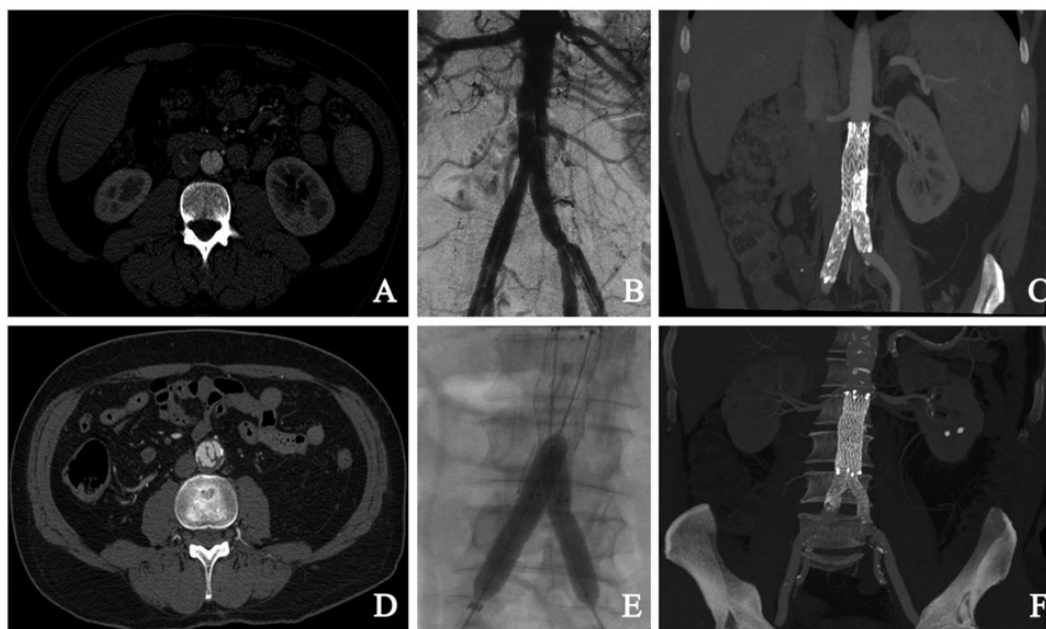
Preoperative CTA showing “double-barreled” appearance of the abdominal aorta (a). Completion angiogram after bifurcated stent graft deployment (b). CTA 8 years after treatment showing good placement of the stent graft without any recurrence (c). CT scan axial image showing abdominal aortic dissection involving to iliac arteries (d). Intraoperative digital subtraction angiography demonstrating good placement of aortic and kissing bare metal stents (e). Postoperative CT scan showing good patency of aortic and iliac stents and complete disappearance of false lumen (f).
